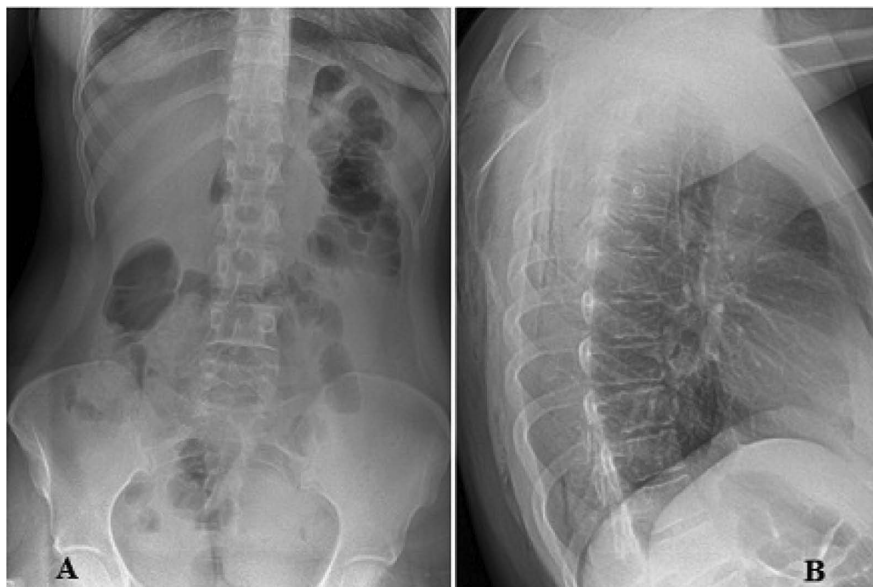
Plain radiography of thoraco-lumbar spine from anterior-posterior (A) and lateral view (B).
